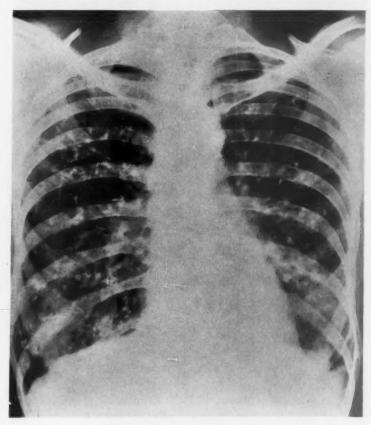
Chest x-ray, July 8, 1948.
